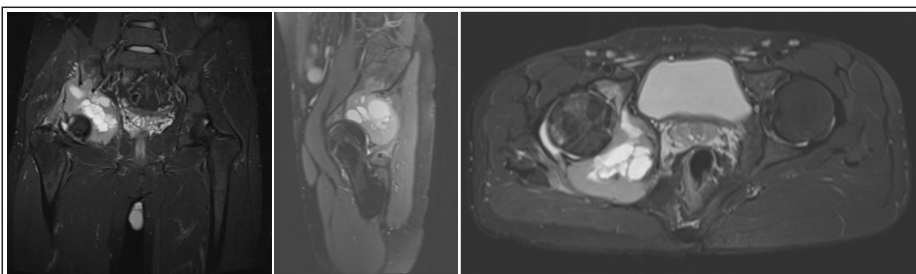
MRI images showing posterosuperior soft-tissue involvement by the tumor.
